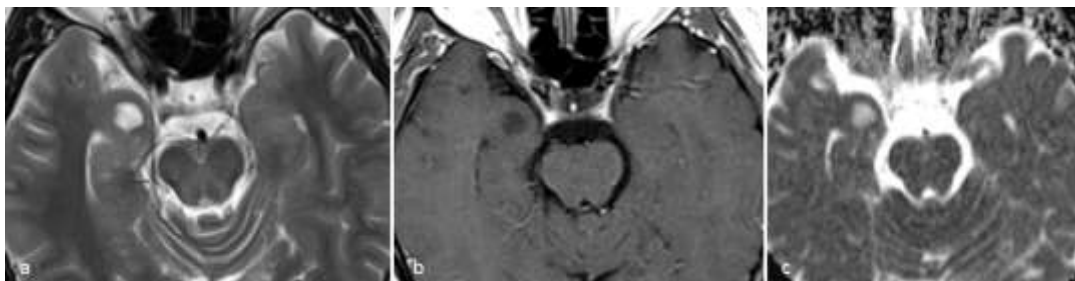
Axial T2-weighted (a), T1-weighted (b) images and apparent diffusion coefficient map (c) show a DNET in the right uncus.
